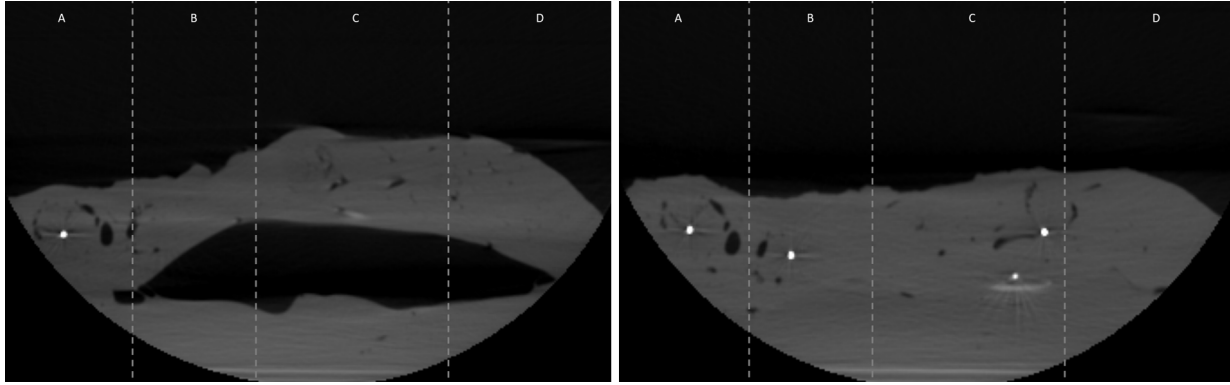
Inflation of the sachet. F.l.t.r: Inflation of 60% with in black the inflatable, and the white dot is T7. The figure shows four zones (A, B, C, and D) that each experience a different inflation magnitude. A is outside the blow zone, B is subjected to the incline of the sachet with a big variability, C is rather constant, and D is the decline of the sachet. T7 is located in zone A, while the catheter is located in a different blow zone (B) of the inflatable sachet, and therefore not taken into account in the results. - Right picture shows inflation of 0%, this clearly shows that T7 is not influenced properly by the inflation sachet, the catheter marker is not shown since it is on a different CBCT slice.
